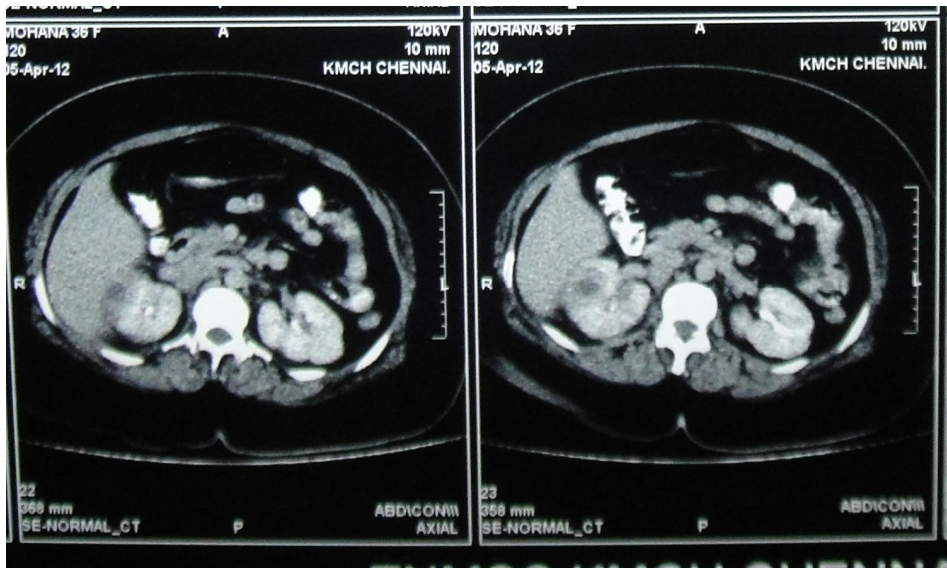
CT Scan of Patient Number 2 with Left EPN
